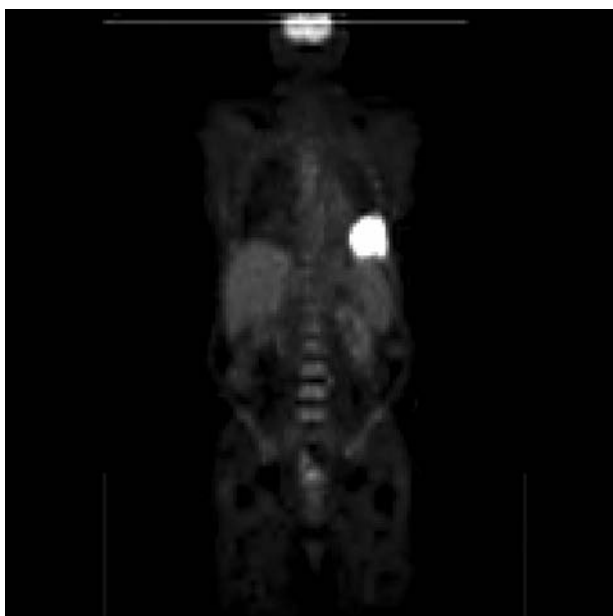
Fused PET-CT scan revealing that previously seen left lower lobe mass demonstrates avid FDG uptake with maximal standardized uptake value of 37.24. The mass appears stable in size and is about 3 × 2.1 in. There is small non-FDG avid left pleural effusion.
